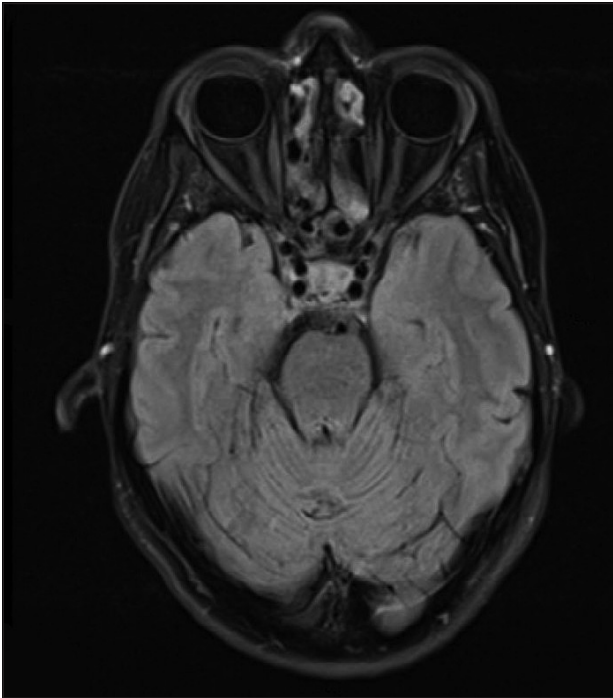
Brain MRI in T2W/Flair mode (axial plane) shows no atrophic changes in the cerebellum.
